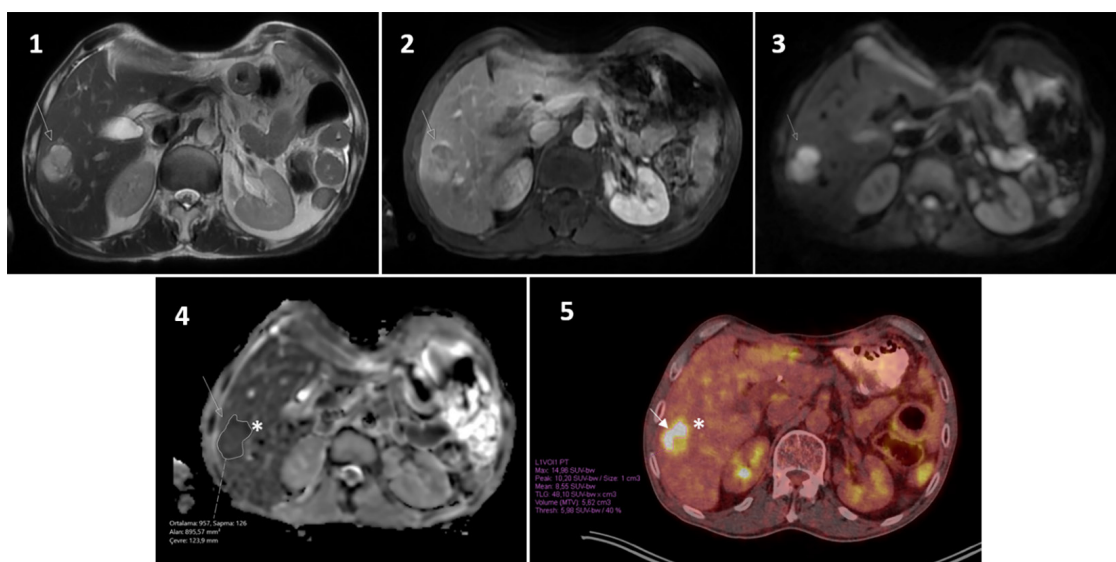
A 58-year-old male patient with metastatic gastric adenocarcinoma/systemic treatment response evaluation (MRI and PET/CT scans) 1–5 Axial T2, contrast-enhanced fat-suppressed T1, DWI, ADC, and PET/CT images from 1–5 show liver metastasis, respectively (white arrow). The 4th figure shows the ROI for the ADC measurement, and the 5th figure shows the VOI (volume of interest) for the SUV measurement (*). $ADC_{min}: 0.68 \times 10^3 \text{ mm}^2/\text{s}$, $ADC_{mean}: 0.96 \times 10^3 \text{ mm}^2/\text{s}$, $ADC_{max}: 1.25 \times 10^3 \text{ mm}^2/\text{s}$, $SUV_{mean}: 8.6$, $SUV_{peak}: 10.2$, $SUV_{max}: 15$ were calculated.
